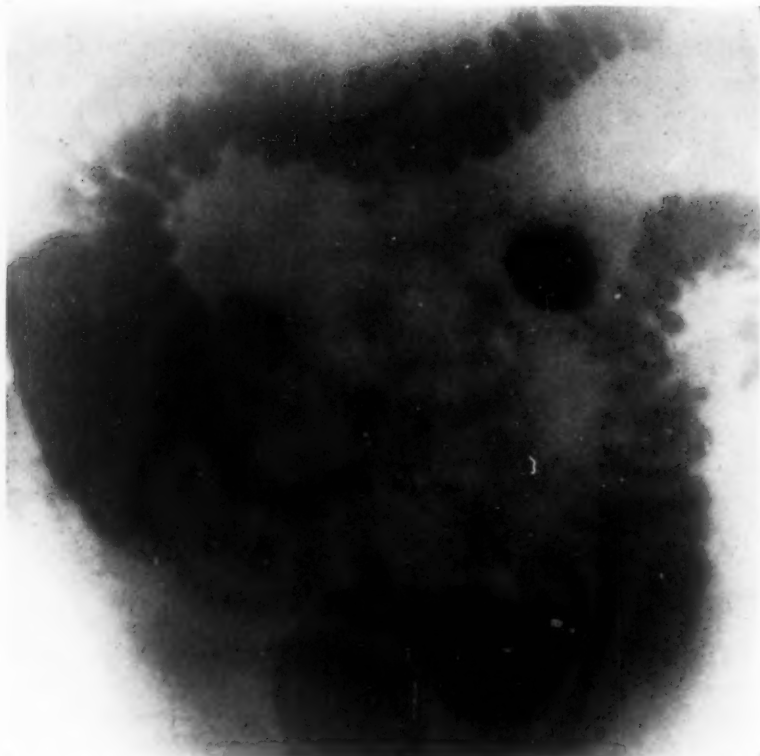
Radiograph twenty-eight hours after meal and after catharsis and ten minutes after enema and before evacuation. Shows two large diverticula of the upper ileum and multiple diverticula of the colon.
